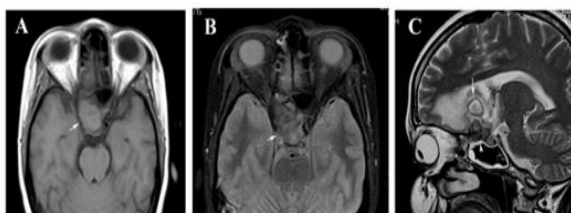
MRI features of Chronic Granulomatous Invasive Fungal Sinusitis (CGIFS) with orbital apex and intracranial involvement. (A) Axial T1-weighted image demonstrates an isointense soft-tissue mass involving the right orbital apex with suprasellar extension (arrow). (B) Axial T2-weighted image shows the lesion to be isointense (arrow). (C) Sagittal image reveals a hypointense suprasellar component with an associated small conglomerate abscess in the right frontal lobe and surrounding vasogenic edema, indicating intracranial spread. (D) Axial contrast-enhanced T1-weighted image demonstrates a heterogeneously and intensely enhancing mass in the right orbital apex. (E, F) Coronal and sagittal contrast-enhanced T1-weighted images show the orbital apex lesion with ring-enhancing intracranial abscess formation in the right frontal lobe, confirming intracranial extension of CGIFS.
